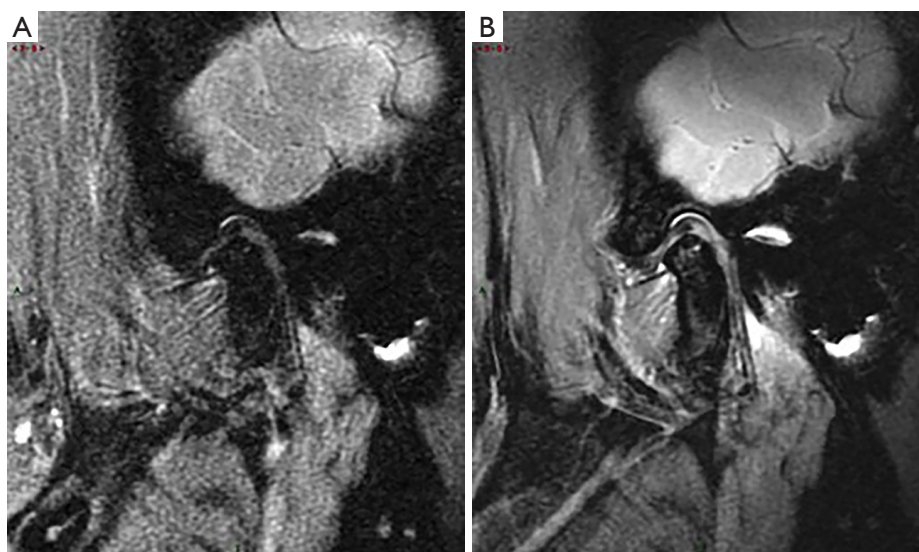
Display of the condylar osteophyte and erosion of the TMJ. (A) The conventional HNCC MRI image cannot show the boundary and extent of condylar osteophyte and erosion clearly enough, and subjectively, the overall image noise is higher than that of the WD-HNCC MRI image. (B) The WD-HNCC MRI image can more clearly show the boundary, extent, and morphology of osteophytes and erosion. TMJ, temporomandibular joint; HNCC, head/neck coupling coiling; MRI, magnetic resonance imaging; WD-HNCC, wireless detector–head/neck coupling coiling.
